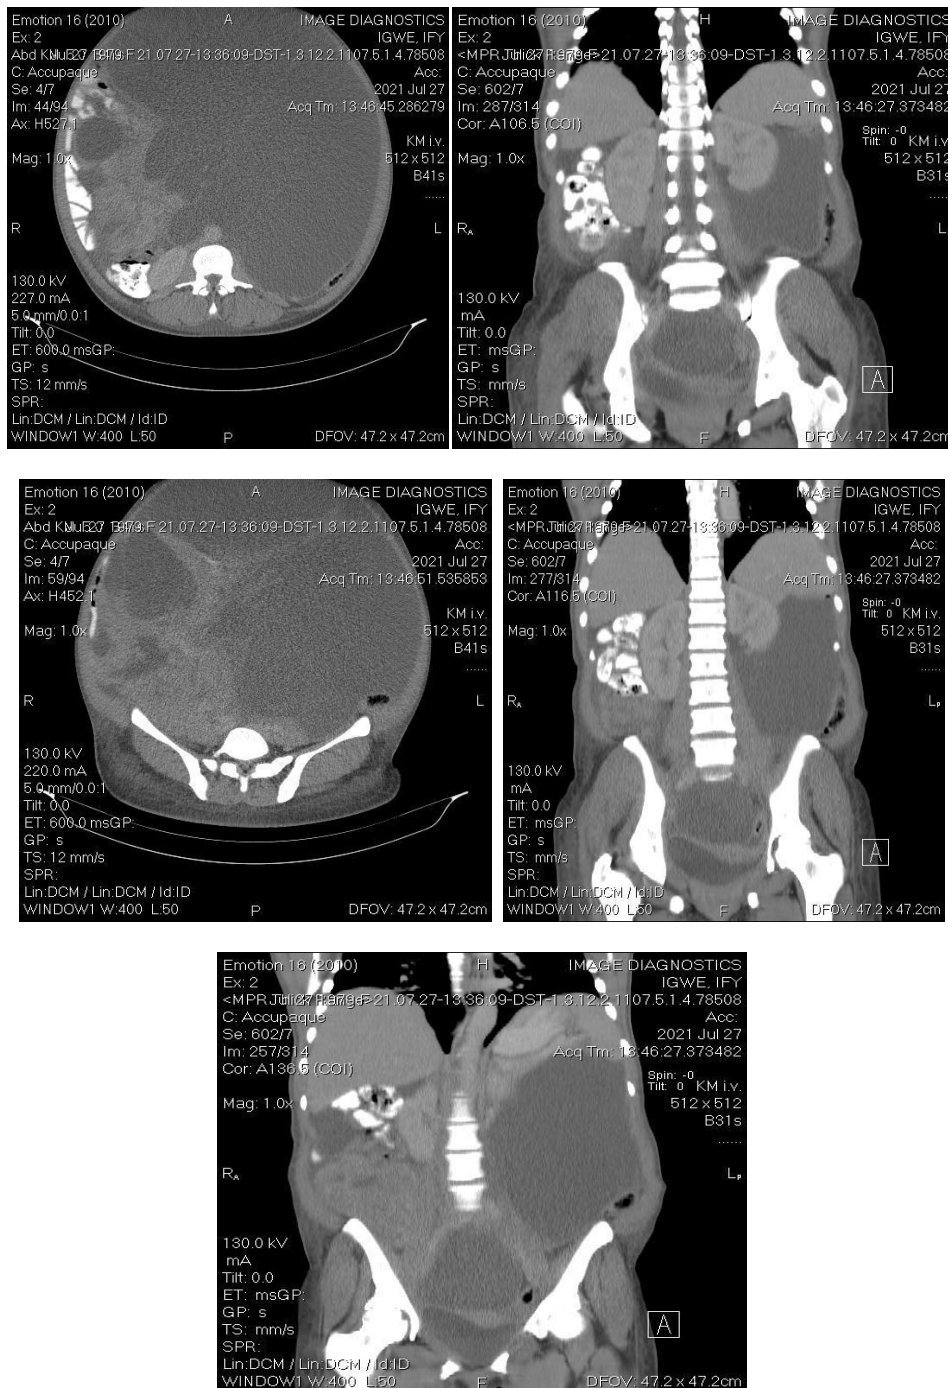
Abdominal CT showing a voluminous cystic lesion causing a displacement and compression of the bowel loops in the right upper abdomen
